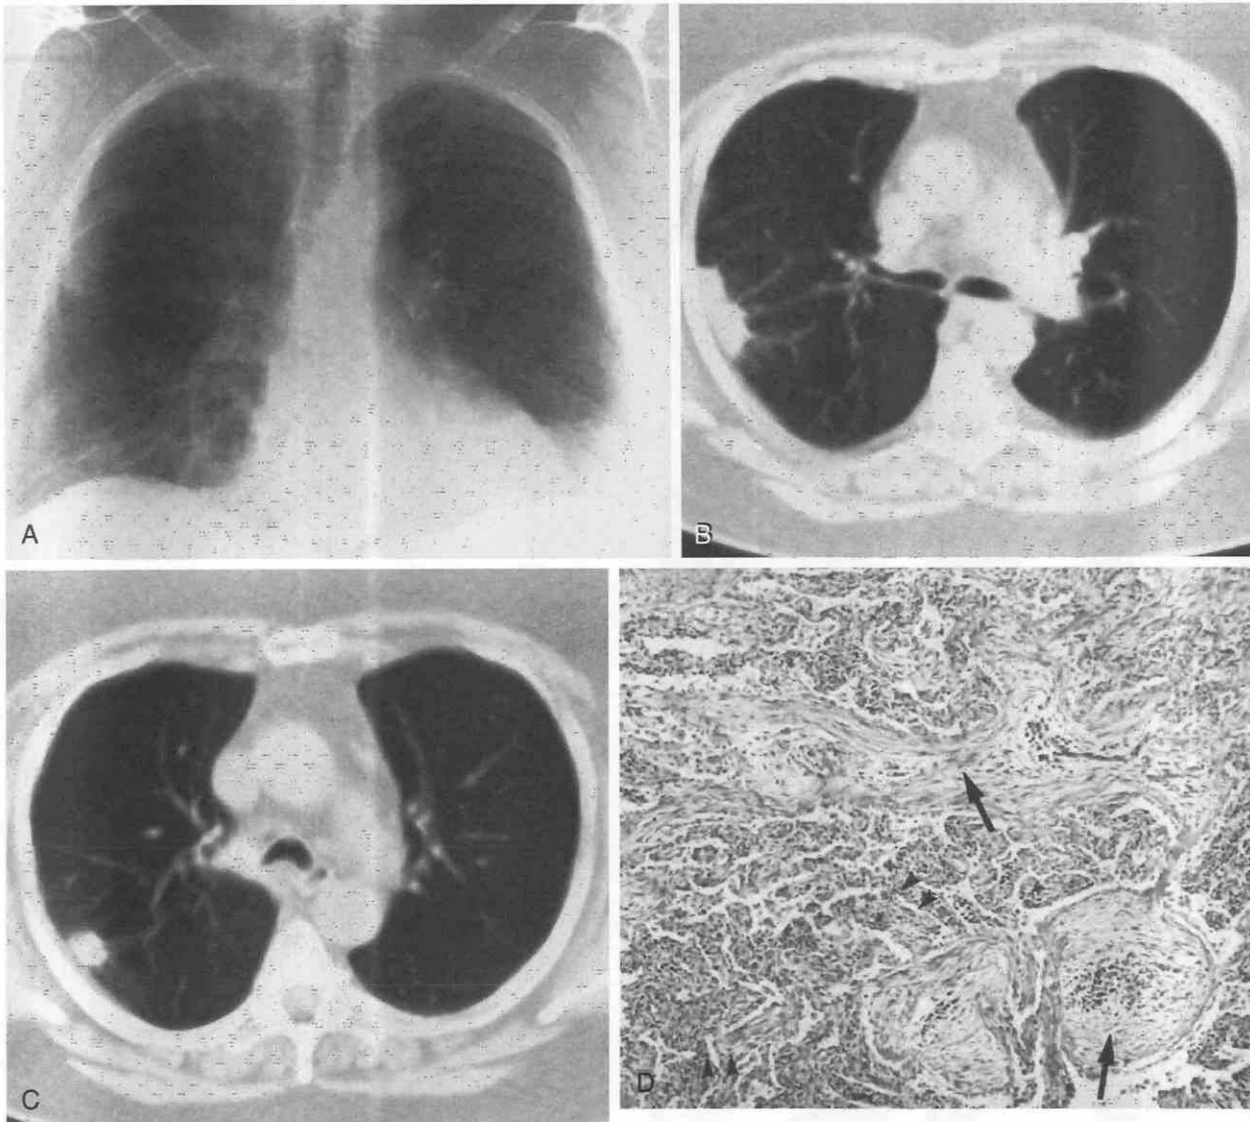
CT features of bronchiolitis obliterans with organizing pneumonia (BOOP).
